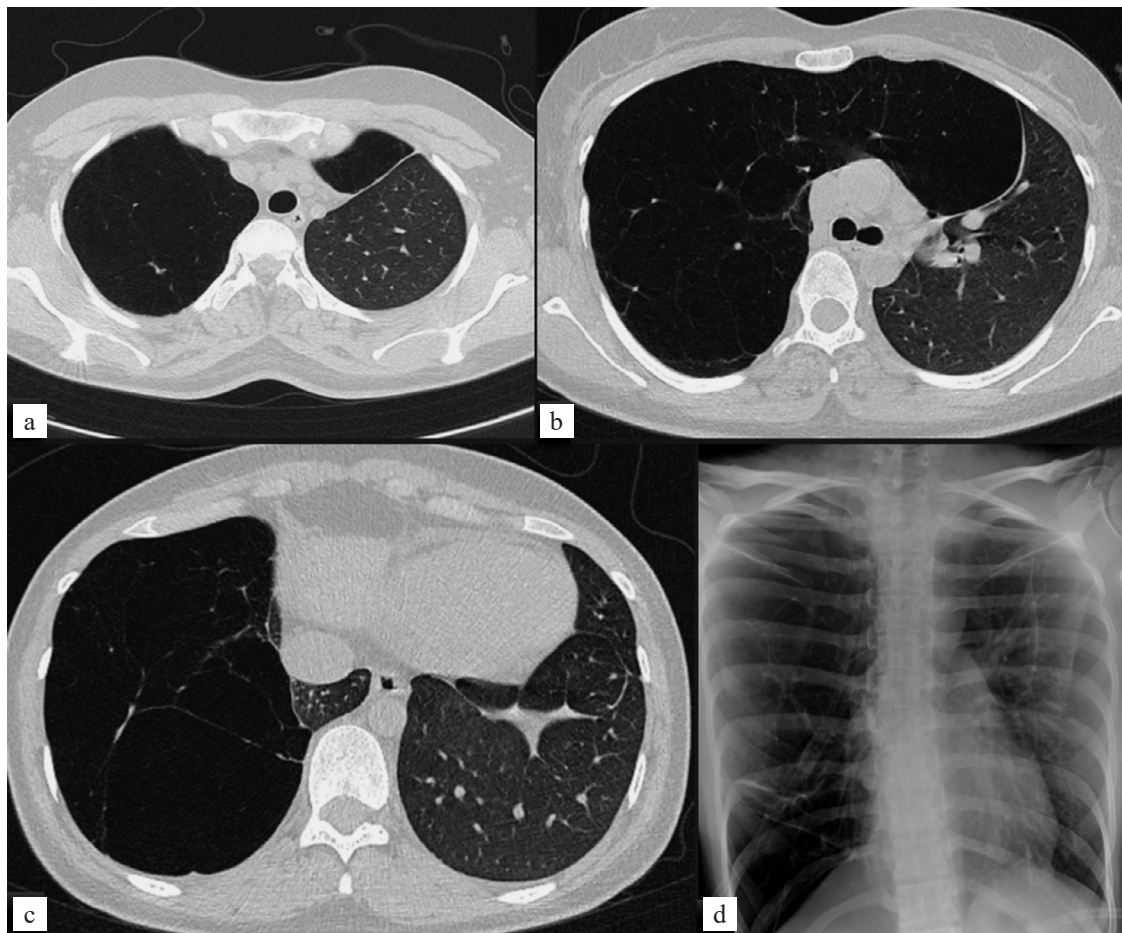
Radiological findings prior to surgical intervention: a, 3rd thoracic vertebra; b, 5th thoracic vertebra (tracheal bifurcation); c, 7th thoracic vertebra (beginning of the diaphragm); d, frontal chest X-ray
